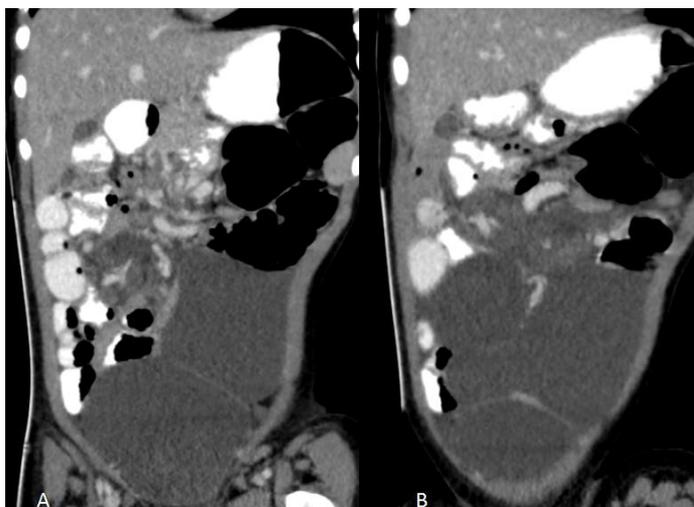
(A-D)-Contrast enhanced CT abdomen showing counterclockwise barber pole sign distal to root of mesentery (SMV showing counterclockwise rotation with relation to SMA)
